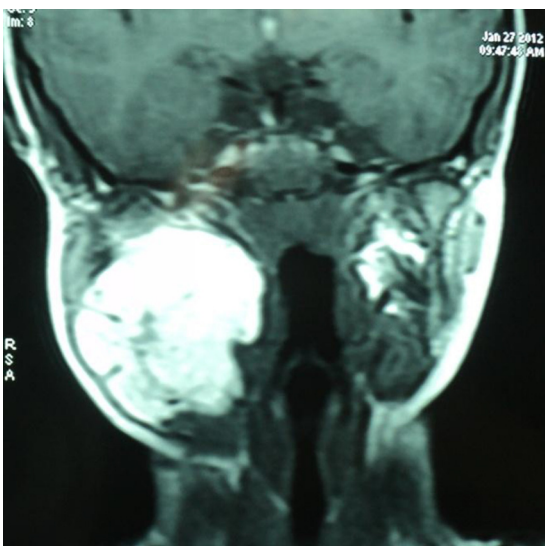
MRI neck showing a high signal intensity of the mass equivalent to that of fat on T1 weighted image in parapharyngeal space.
